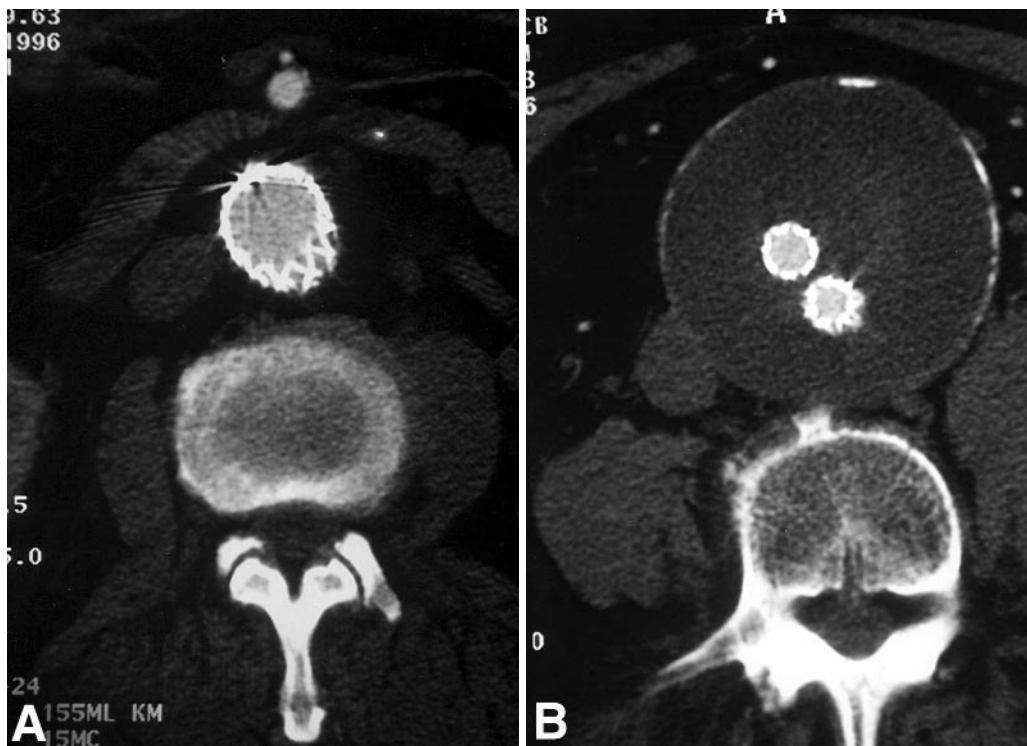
Computed tomography scan of the same patient seven months after endoluminal grafting of the AAA. The size of the neck (A) had not changed significantly. Contrast is seen only in the aorta and inside the graft. The size of the aneurysm sac has increased (B) although endoleak is not evident.
